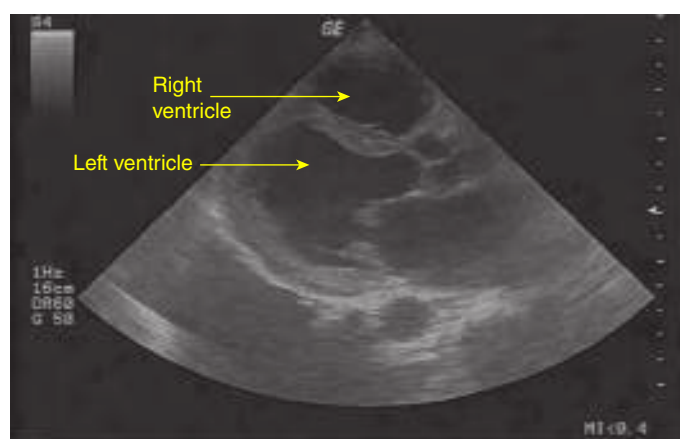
Parasternal long axis view of the heart in a patient with CHF. The enlarged left ventricle has limited contractility and a poor ejection fraction.
